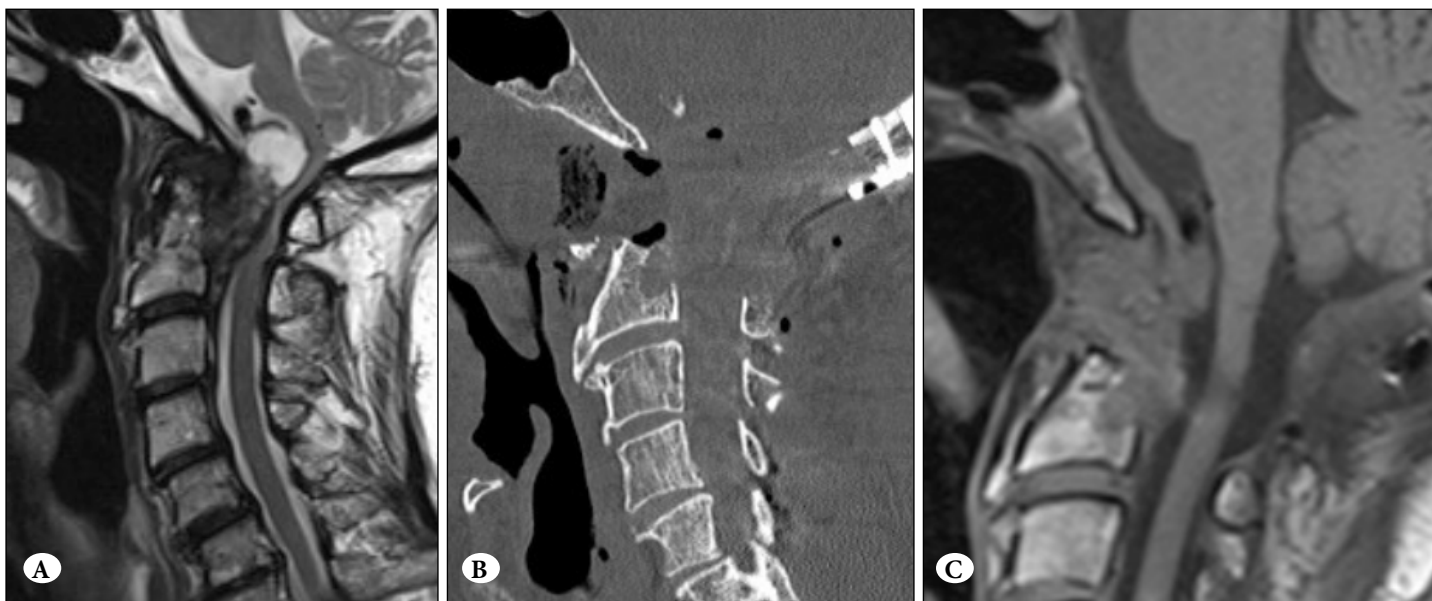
A) Preoperative MRI (sagittal T2-weighted image), showing an inflammatory pannus dorsal to the odontoid process and compressing the upper cervical spine and lower brainstem. The patient had signs and symptoms of myelopathy. B) Postoperative image of the same patient following staged dorsal decompression and instrumented occipito-cervical fusion, followed by endoscopic endonasal odontoidectomy. This sagittally reconstructed CT of the cervical spine demonstrates adequate anterior bony decompression by the endoscopic endonasal approach, with interval removal of the dens and the C1 anterior arch. C) Six-month post-operative MRI (sagittal T1-weighted image) showing resolution of the ventral compression.
